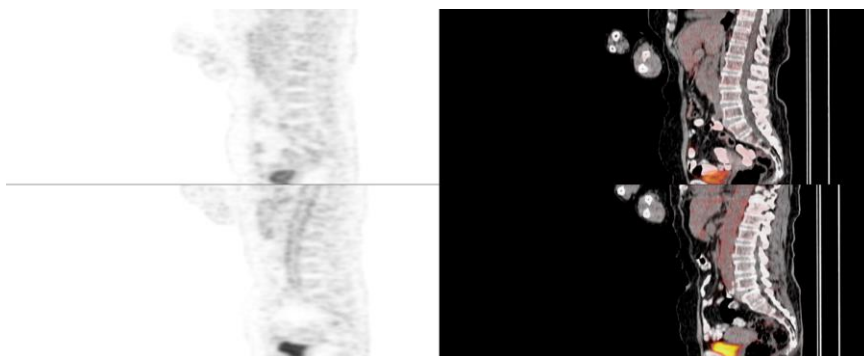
65 years old female patient with suspicion of malignancy who had cystic lesion of pancreas was referred. The PET/CT images revealed severe vasculitis involvement of carotid, subclavian, thoracic and abdominal aorta.
